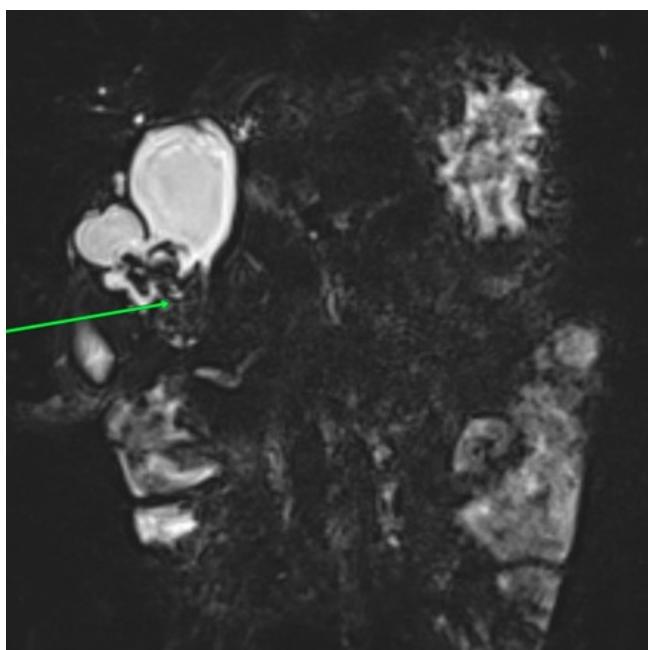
Coronal section of the 3D BILI sequence on MRI, showing a functional bilio-digestive diversion with regression of the volume of the large biliary cyst after drainage
